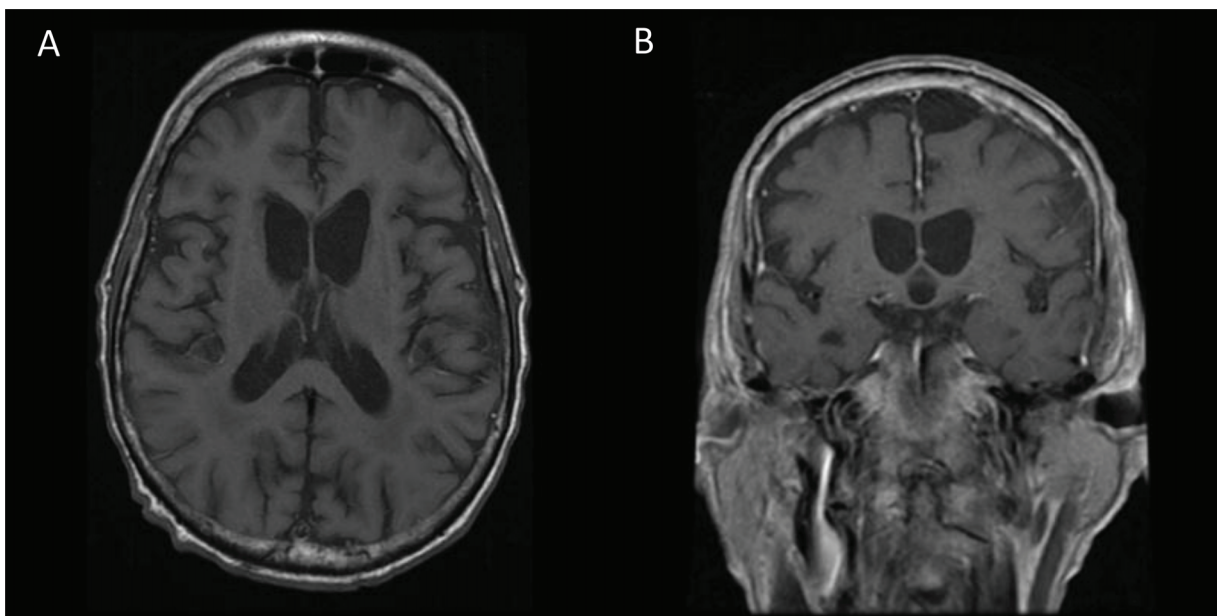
Neuroimaging Study. Magnetic resonance imaging of the brain axial T1 (A) and coronal T1 (B) Axial T1 and coronal T1: bilateral caudate atrophy with global parenchymal loss.
